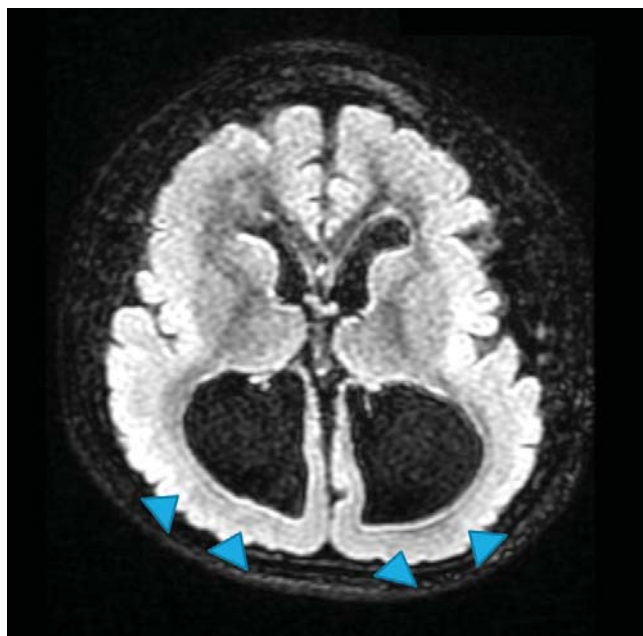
Cerebral MRI T1 Axial View. Ventriculomegaly (arrows).
